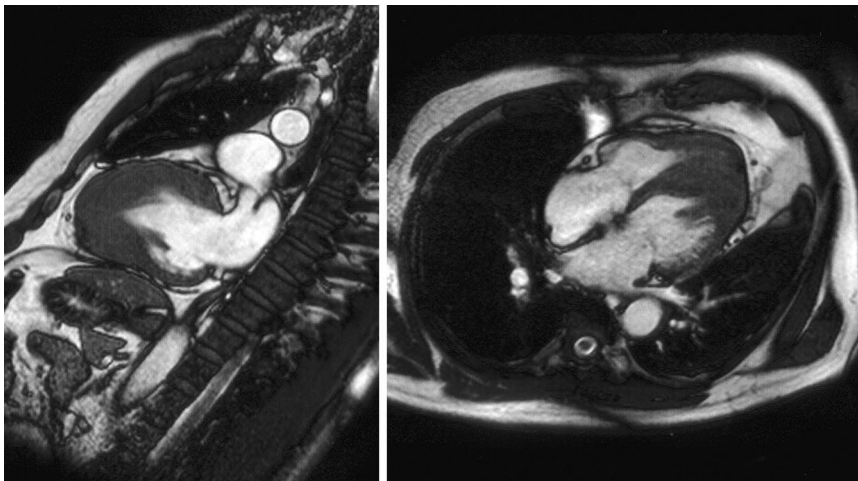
MRI revealed severe hypertrophy confined to left ventricular apex, suggesting apical HCM.
